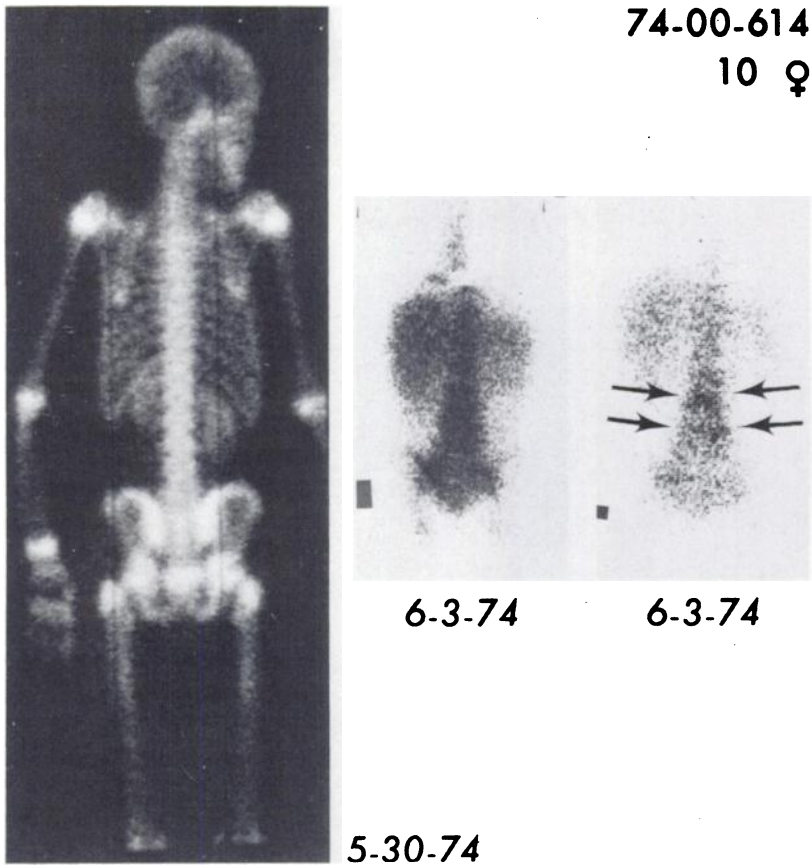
A 10-year-old girl developed fever and severe back pain. X-rays of the spine were normal. Tc-99m HEDP bone scan was normal (5-30-74). Gallium-67 citrate scans at different intensities on 6-3-74, demonstrated bilaterally increased activity in the paraspinal areas corresponding to the para-aortic nodal chains (arrows; see "normal" Fig. 1 for comparison). Blood cultures and surgical biopsy of nodes both produced *Staph. aureus* as cause of bacteremia and sepsis.
